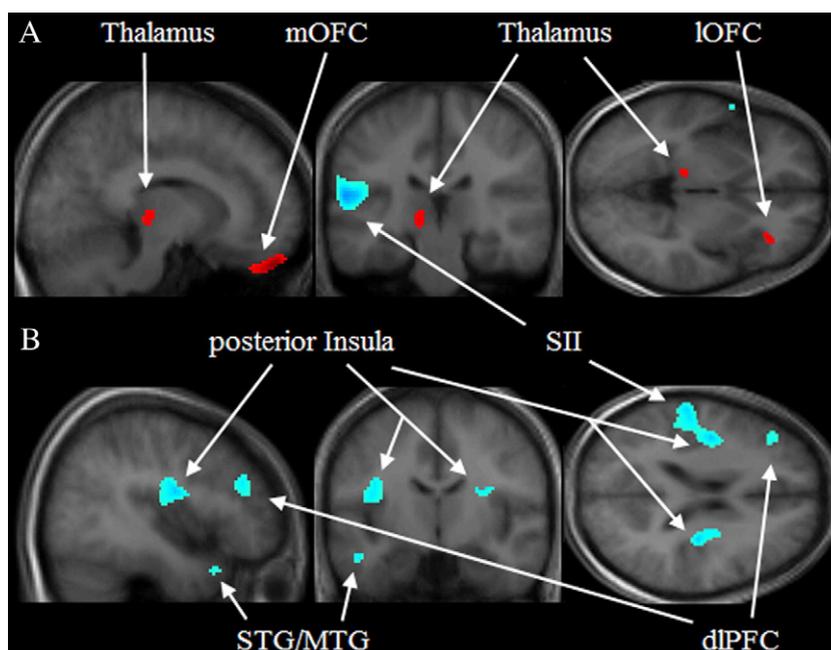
Increased and decreased regional cerebral glucose metabolism at onset vs. offset of primary dysmenorrhea. Onset of PDM was associated with (A) increased activity in the left medial orbitofrontal cortex (mOFC), right lateral orbitofrontal cortex (IOFC, BA 47), and left thalamus and (B) decreased activity in bilateral posterior insula, left secondary somatosensory area (SII), left dorsolateral prefrontal cortex (dlPFC, BA 8/9), and left superior and middle temporal gyrus (STG/MTG, BA 21/22/38). Results are superimposed on the averaged anatomical T1 MRI from patients. Red/blue color represented activation/deactivation.
